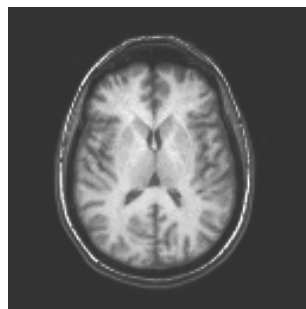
(a): A T₁-weighted MR image (left) used for synthetic intra-modality registration.
